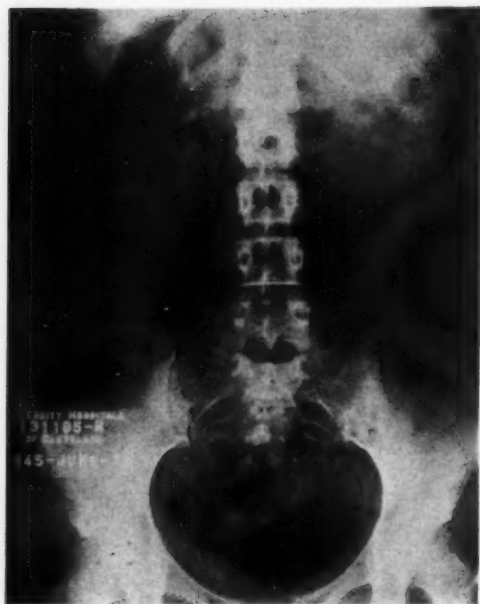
Case III: Abdominal roentgenogram of patient with colicky abdominal pain due to acute porphyria. Segmental gaseous distention of small intestine and colon.
